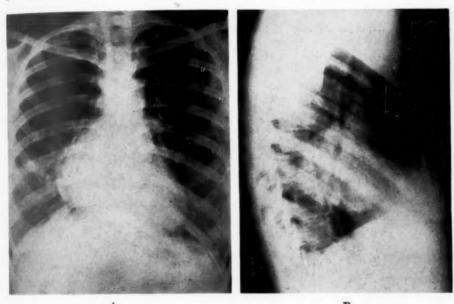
Case 4: A. Postero-anterior roentgenogram reveals area of density merging with right heart border. Note infiltration in right lower lung field.
